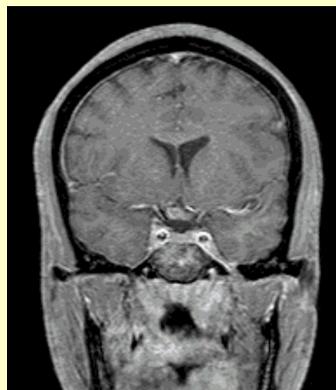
Coronal T1 MRI demonstrating optic chiasm abscess
